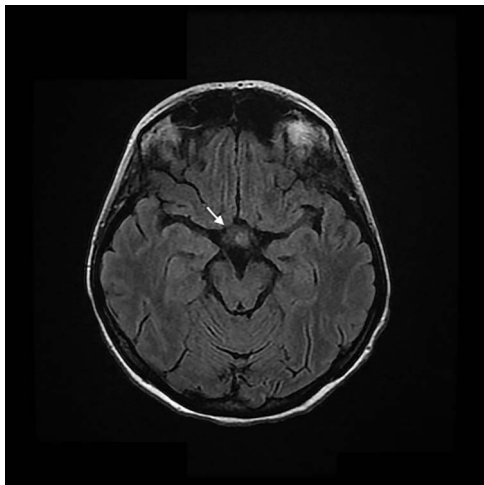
Brain-MRI scan. Axial T2-weighted FLAIR sequences reveal an irregular soft tissue intensity of the infundibulum of the pituitary gland (white arrow)
